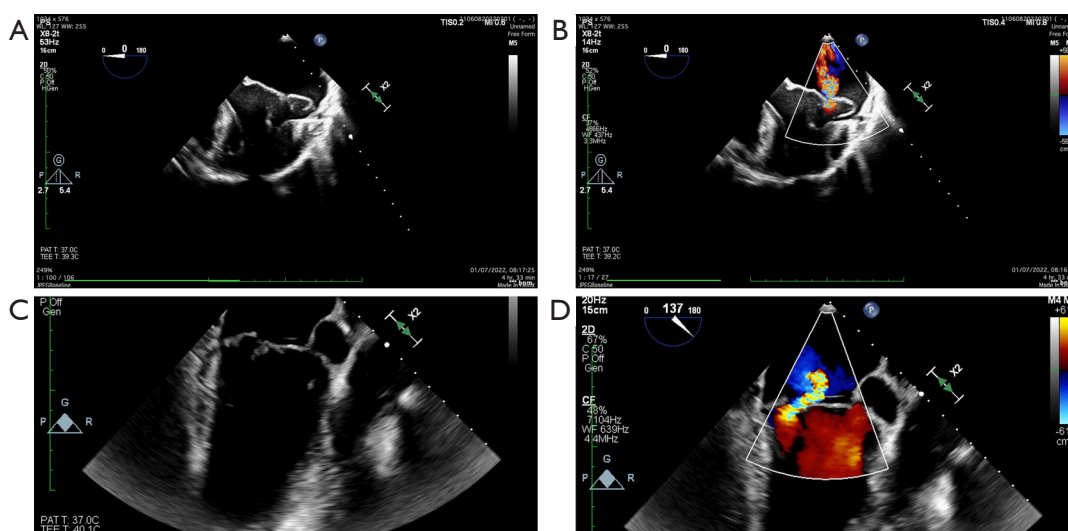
Echocardiographic imaging of symmetric and asymmetric regurgitant jets in Barlow's syndrome. Transesophageal echocardiography image showing bileaflet mitral valve prolapse (A). Corresponding image demonstrating a symmetric regurgitant jet (B). Transesophageal echocardiography of posterior leaflet prolapse (C) with an asymmetric regurgitant jet (D).
